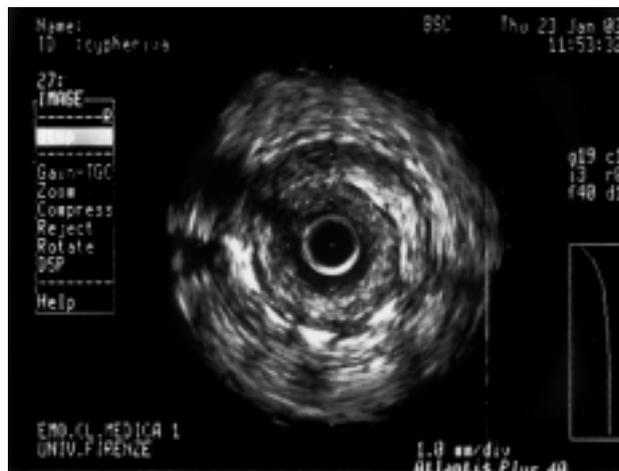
Intravascular ultrasound confirmed an impressive in-stent proliferation in the right coronary artery.
